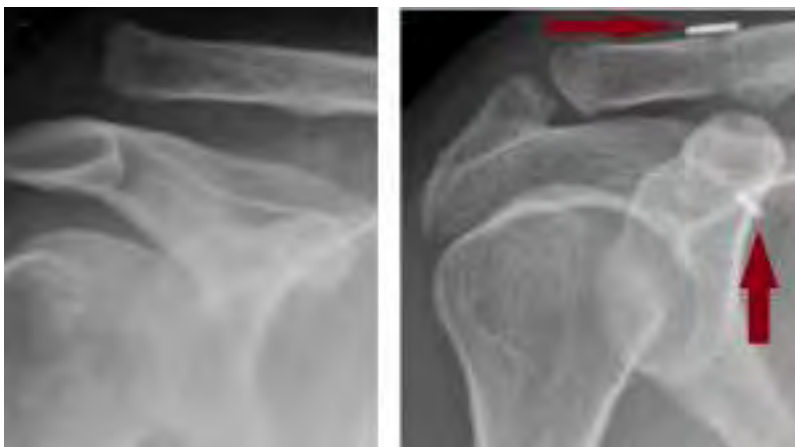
An AC separation is shown at left. In the x-ray to the right, arrows point to the buttons used to anchor the suture holding the clavicle in the appropriate position during healing. (From Montoya et al. (2019) Surgical Treatment of High Degree AC-Joint Dislocations Using Double-Button Fixation Device. BAOJ Ortho 4: 025)
